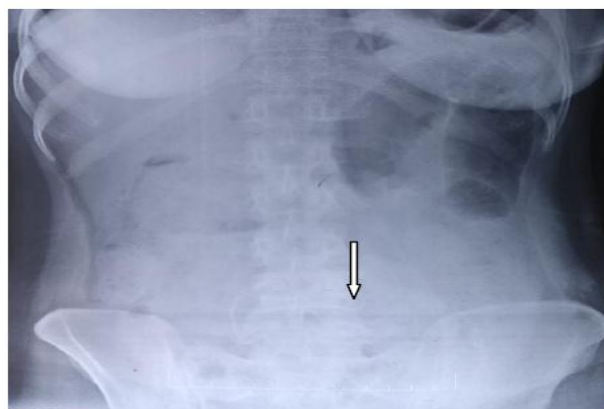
Abdominal x-ray revealed an added radio-opacity in the lower abdomen (figure: 1).
